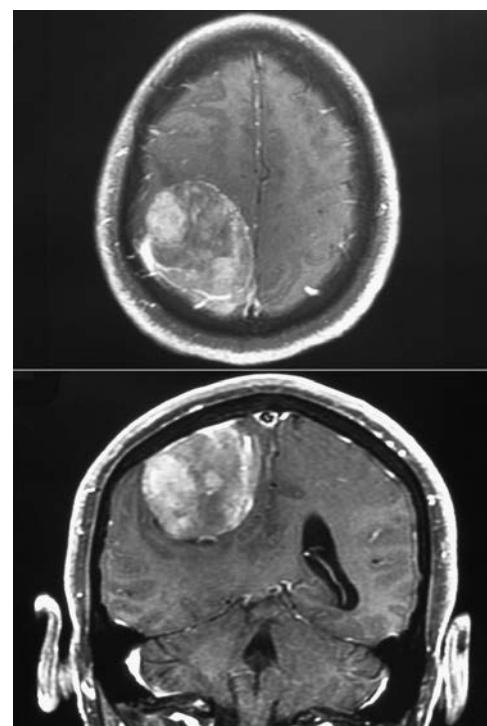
Axial (top) and coronal (bottom) magnetic resonance images of a parasagittal meningioma. Resection of meningiomas arising from the dural reflection overlying the sagittal sinus or from the dura of the adjacent convexity or falk often entails a risk of venous air embolism because of the proximity of the sagittal sinus (the triangular structure at the superior end of the interhemispheric fissure in the bottom panel).
